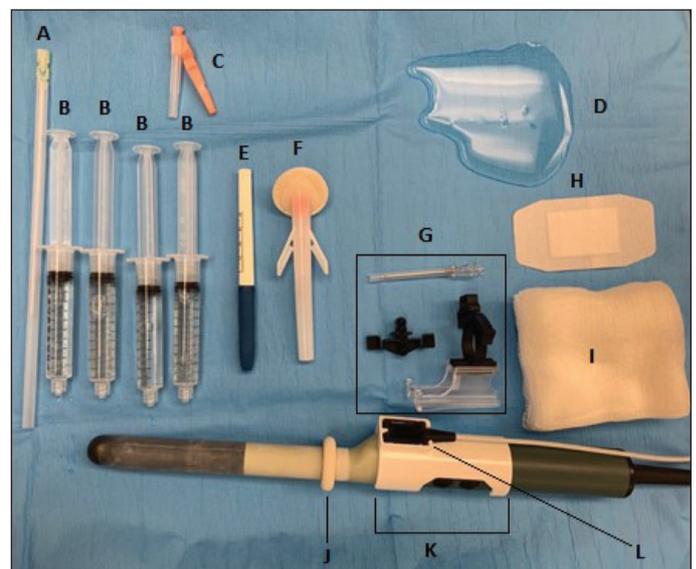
Setup/supplies for transperineal fusion biopsy. (A) 20-gauge 6" spinal needle; (B) 10 cc of 10:1 1% lidocaine mixed with 8.4% sodium bicarbonate; (C) 22 g needle; (D) surgical lubricant; (E) marking pen; (F) 2% chlorhexidine; (G) PrecisionPoint Transperineal Access System; (H) bandage; (I) 4x4 surgical dressing; (J) disposable probe cover; (K) tracker mount; (L) tracker for field generator. Probe pictured is the bK 8848 Biplanar Ultrasound Probe.
